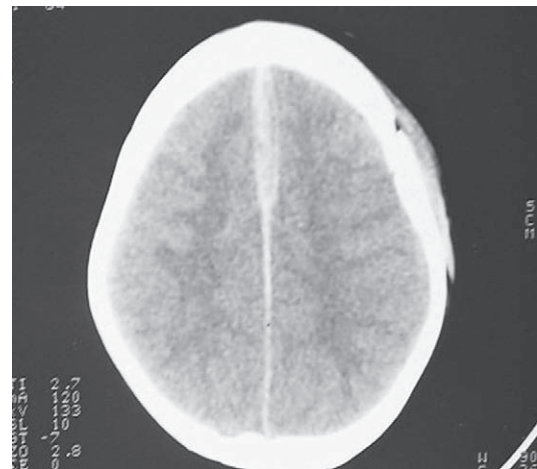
CT showing ISDH involving anterior falx
